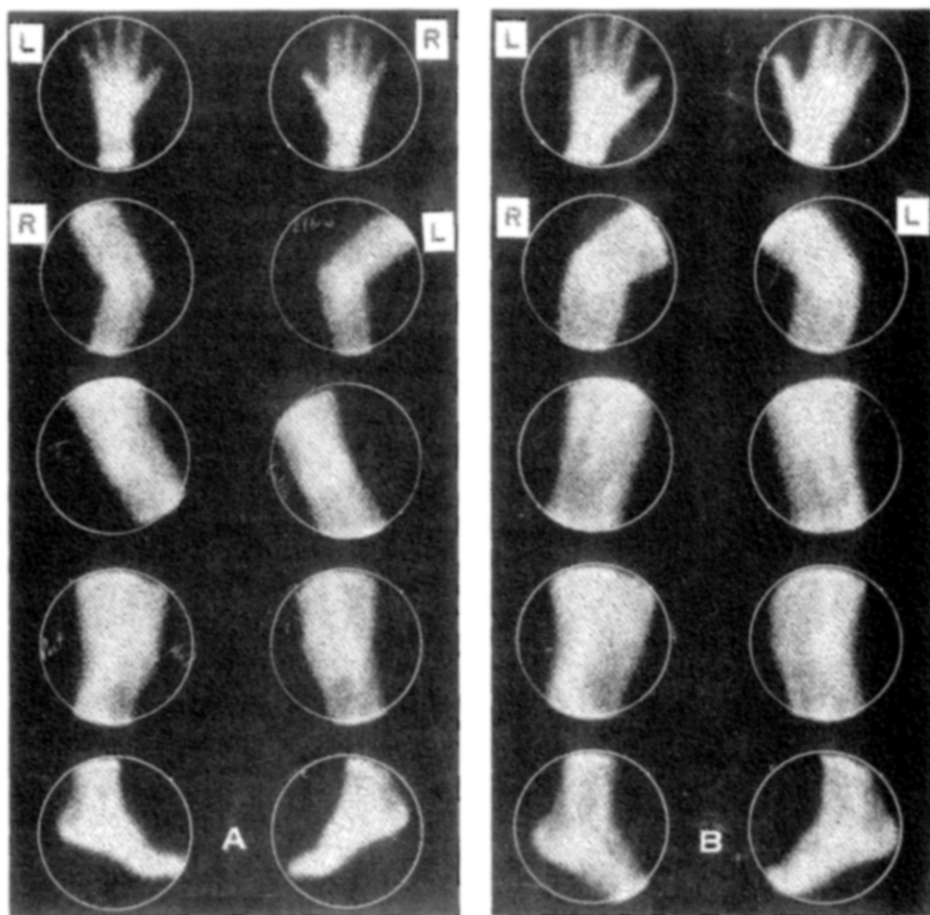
$^{99m}\text{TcO}_4^-$ synovial membrane scans of two patients with joint pain and normal roentgenograms. In both patients laboratory studies were normal and physical examination was equivocal for arthritis. (A) Normal pattern. Follow-up on this patient for 1 yr has shown no objective evidence of arthritis. (B) Positive localization in right third MCP joint and in both elbows. Scan confirmed that pain in right third MCP was due to synovitis, and detected synovitis in elbows 1 mo before it became significant complaint. Rheumatoid arthritis was confirmed by laboratory studies 1 mo after scan gave first objective evidence of synovitis.
